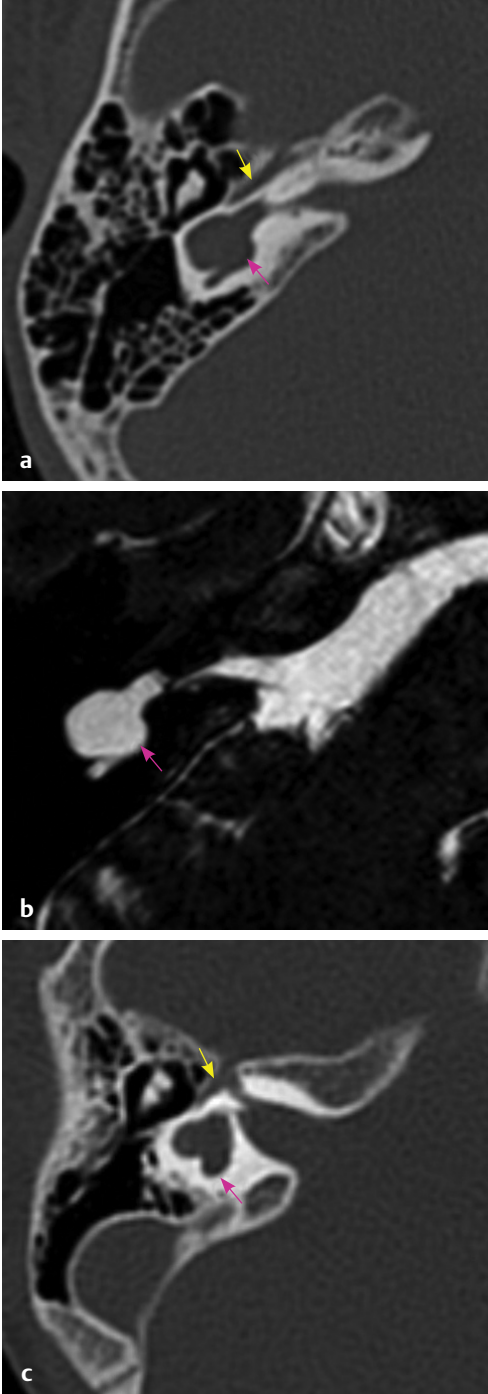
(a, c) HRCT temporal bone, bone window and (b) MRI CISS sequence, axial section shows dilated vestibule (pink arrow) with anteriorly displaced facial nerve (yellow arrow) and absent cochlea.
